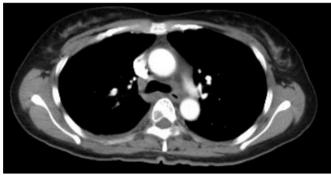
Chest high-resolution CT film. A nodule with marginal irregularity, internal heterogeneity and spiculation was found in the right lung lobs S6. In addition, neoplastic lesions were detected in the second and fourth ribs, with several similar lesions in the spine.
